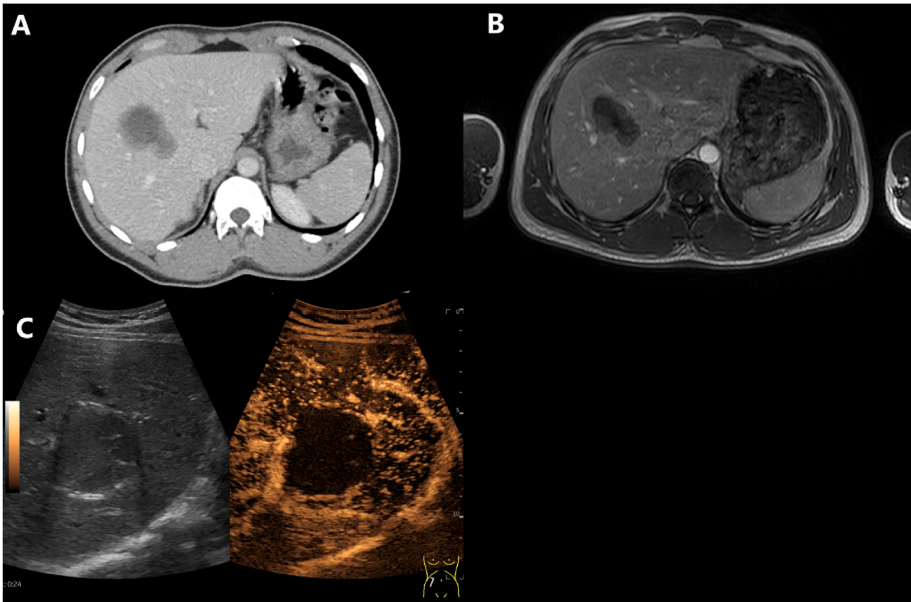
1 A - CT Abdomen: incidental hepatic cyst segment VIII (~4 × 4 cm), calcified rim
